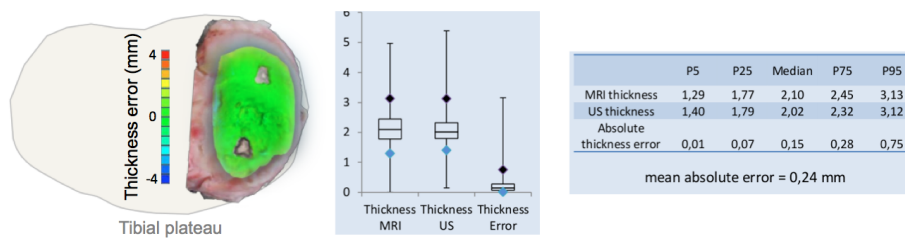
Nine tibial plateaus were scanned using both MRI and US. A low mean absolute error between imaging modes validates the use of US for the measurement of cartilage thickness, and the evenly distributed difference (here, the example of plateau n7 from the set) validates the hypothesis made regarding the ultrasound speed in cartilage.
